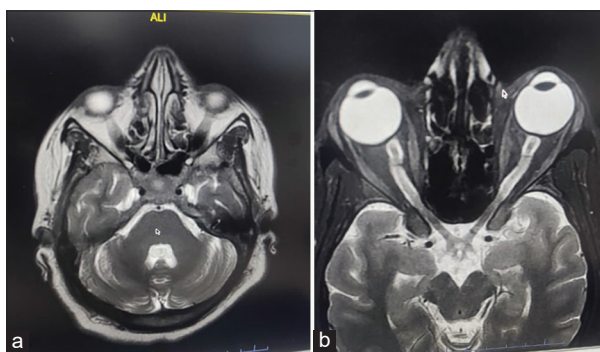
Magnetic resonance imaging brain section showing (a) normal costophrenic angle and no compression of sixth cranial nerve was seen; (b) normal prepontine area and no compression of optic nerve was seen
